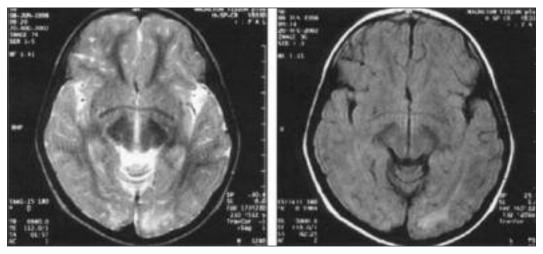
T2 weighted A. and FLAIR B. imagings showing hyperintensity in medial occipital lobes.
